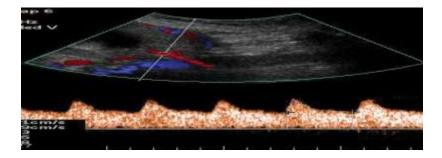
Uterine artery Doppler ultrasound scan showing normal waveform.
